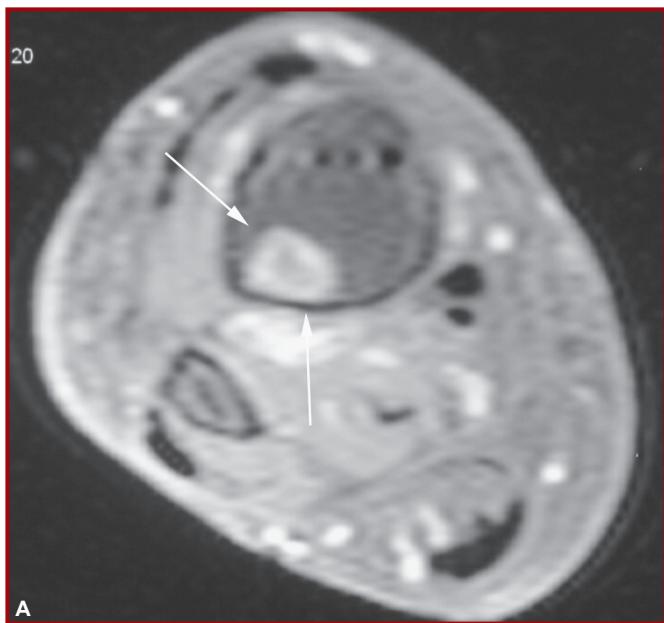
Lesions on the cruris of a 85-year-old patient with cutaneous angiosarcoma. Magnetic resonance images of the distal cruris and foot. In axial gradient-echo series (640/18, flip angle 30°) lesions on both skin A. and subcutaneous tissue (arrows) and B. in the bone marrow (arrows) have high intensity as compared with normal bone marrow
